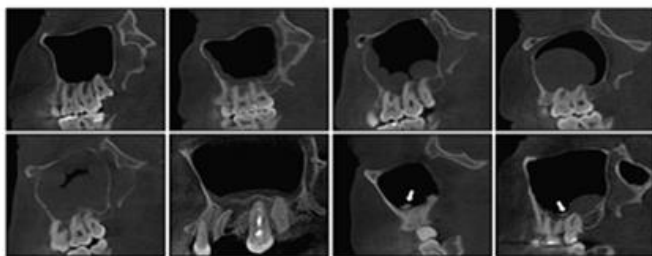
Sagittal sections of cone-beam computed tomography show examples of maxillary sinus abnormalities. A. Normal. B. Mucosal thickening. Sinus polyp. D. Antral pseudocyst. E. Non-specific opacification. F. Periostitis. G. Antrolith. H. Antrolith associated with mucosal thickening. The arrows indicate an antrolith inside the maxillary sinus.
